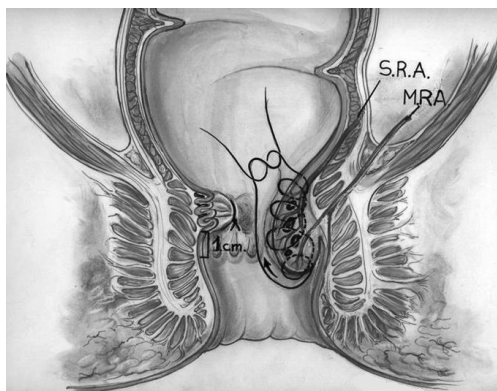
Location of the arterial pulse by Doppler to perform the initial suture. (Source: Carlo Ratto)
